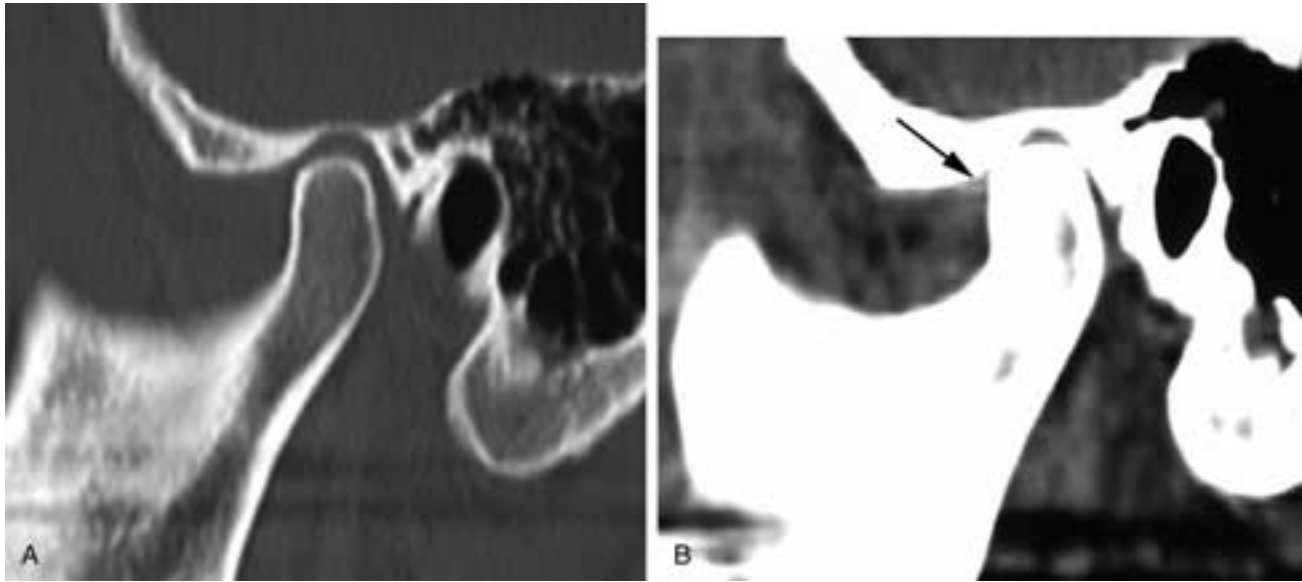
Multidetector CT with sagittal reformats. Normal TMJ. A, Sagittal reformatted image; the bone algorithm shows the normal relationship of the condyle to the glenoid and the articular eminence. B, Soft-tissue sagittal reformat shows a small focus of high density (*arrow*) just anterior to the condylar head. This represents the anterior thick band. This position is considered to be normal.
